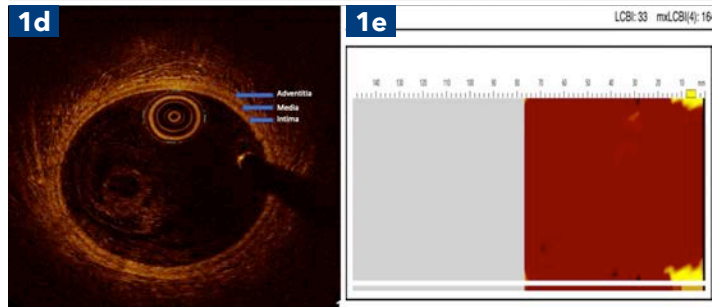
(1d) Combined near-infrared spectroscopy and intravascular ultrasound demonstrates minimal lipid burden. (1e) Optical coherence tomography shows normal right coronary artery.
